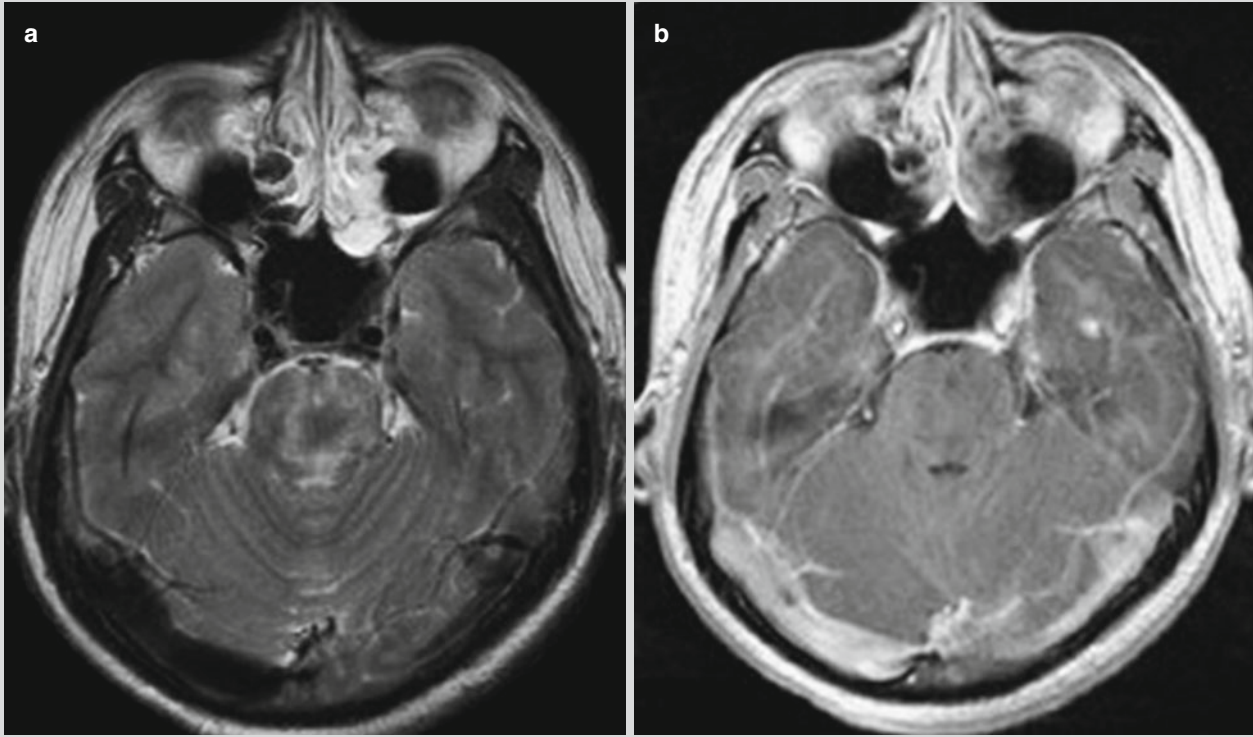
Paratyphoid fever A involving the brainstem. (a, b) MRI demonstrates sheet high signal in the brainstem. (a) Enhancement scanning reveals no obvious abnormal aggrandizement (Reprint with permission from Sheng B, et al. *Neurol Sci*, 2011, 302 (1-2):108)
